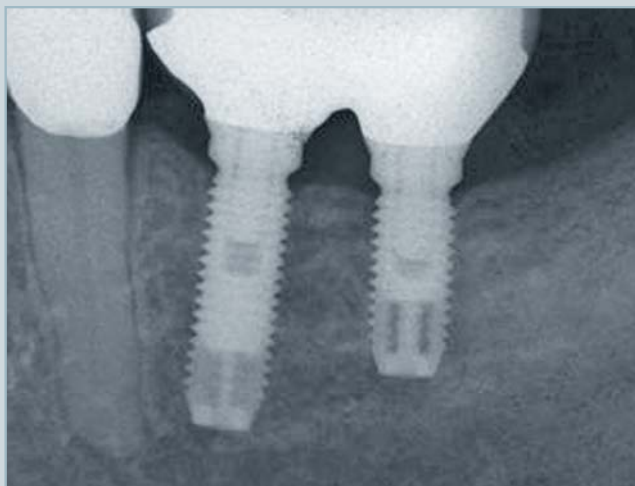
Radiograph demonstrates implant placement. Note the sharp thread lines and clear implant-abutment connection.
